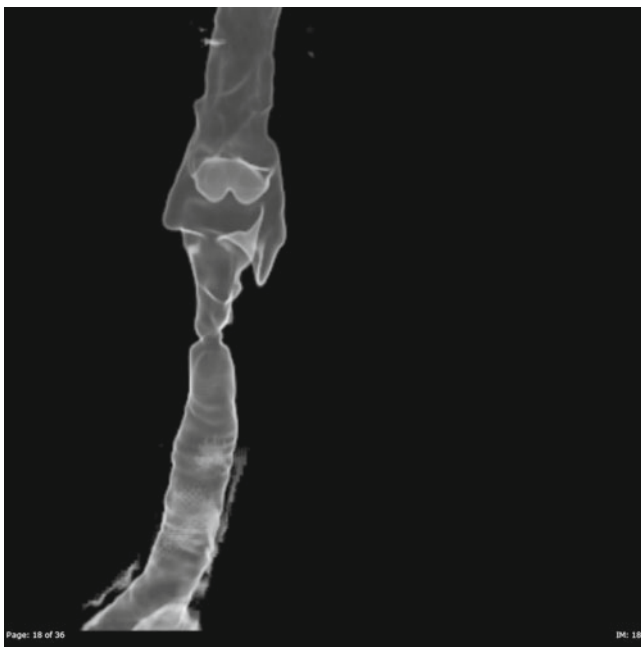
3-D reconstruction of airway. Axial CT data is carefully reconstructed into this three-dimensional image that can be rotated and manipulated. The area of stenosis can be clearly defined in this image
